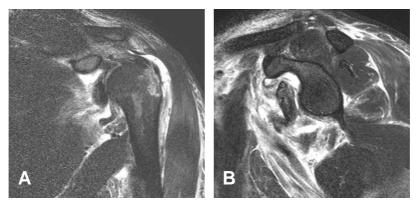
(A) T2 fat suppressed oblique coronal MR image showing a capsular tear with an oblique direction and exposure of the axillary nerve in the same direction at the inferior aspect of the capsular midportion.(B) T2 fat suppressed oblique sagittal MR image showing rupture in the inferior aspect of subscapularis muscle and the exposed axillary nerve.
